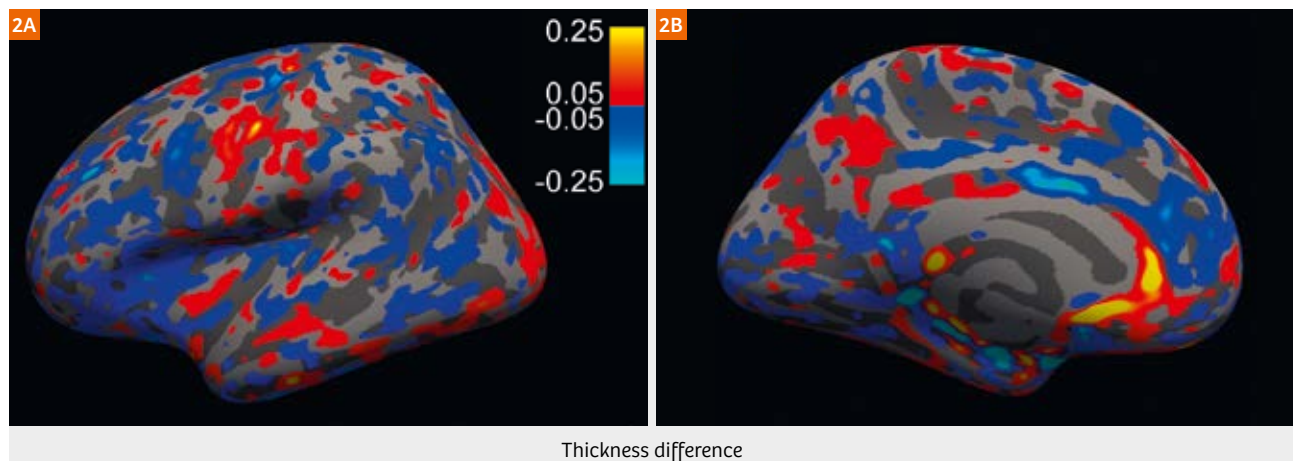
Surface plots of average cortical thickness difference for pairs of T1-weighted images acquired on the MAGNETOM Trio and the MAGNETOM Prisma^{fit}. Thickness differences are threshold at ± 50 – $250 \mu\text{m}$, color bars are in mm. The left hemisphere is shown – results are similar for the right hemisphere.
